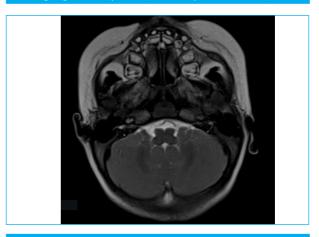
Axial T2 MRI shows normal posterior fossa; medulla and cerebellum (shown by white arrow).
